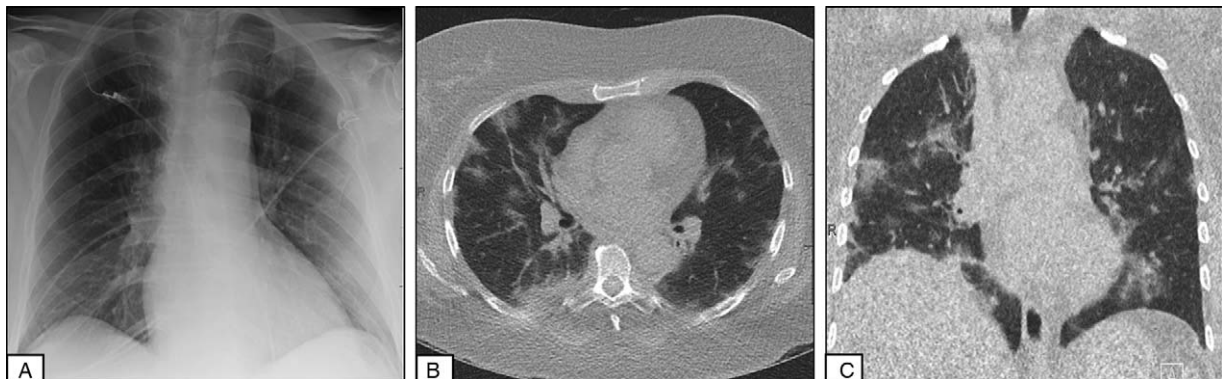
Patient 8: suboptimal, apparently unremarkable chest radiograph (A). Conversely, ultra-low dose CT showed patchy bilateral areas of ground-glass opacifications (B and C).
